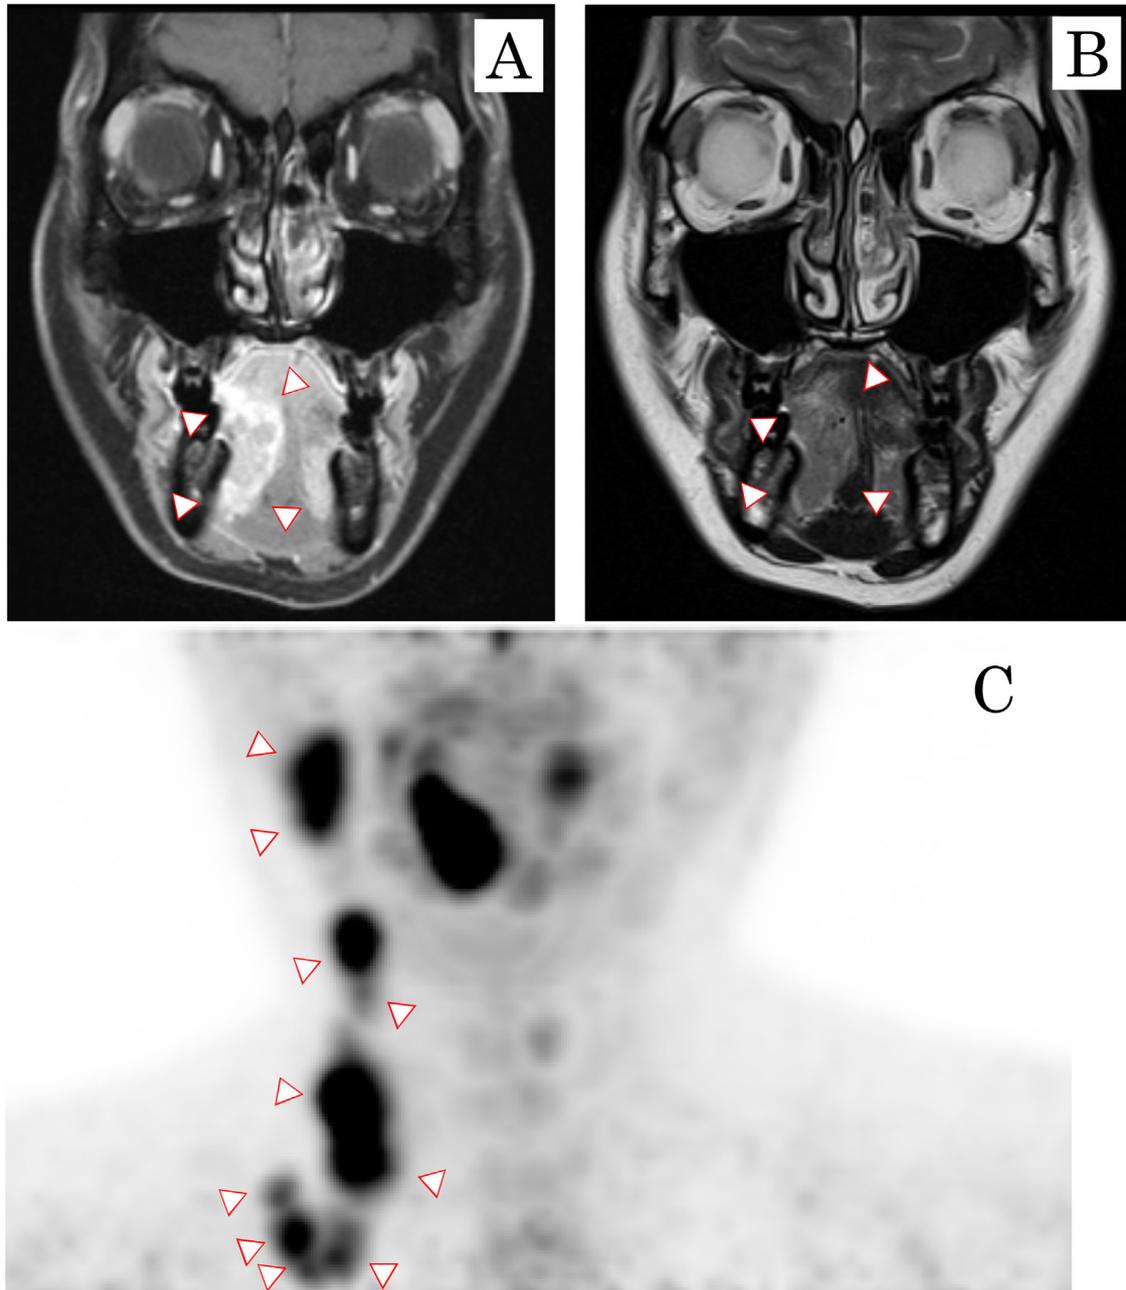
(A) Enhanced T1-weighted magnetic resonance imaging (MRI) revealed a $35 \times 32 \times 16$ mm, heterogeneous, moderate enhanced mass lesion with poorly defined margins in the right side of the oral floor to the lower surface of the tongue. (B) Enhanced T2-weighted MRI also revealed the same mass lesion with high-signal enhanced margins. (C) Positron emission tomography-computed tomography (PET-CT) revealed an accumulation of F-18 deoxyglucose (FDG) in the right submandibular, upper cervical, and peri-clavicular lymph nodes.
